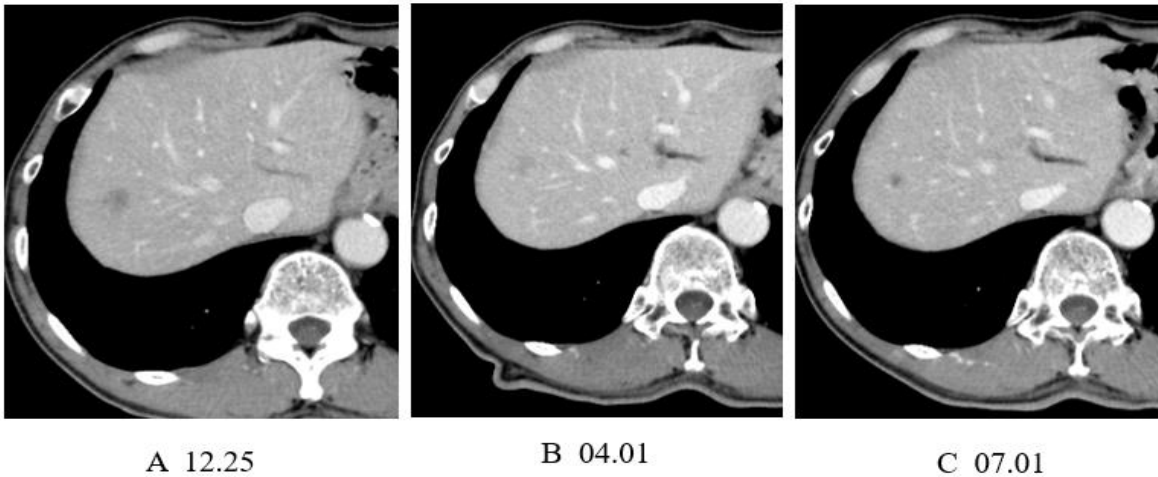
As time went by, a hypo-vascular space occupying lesion at S8 that is suspicious of metastatic tumor from gastric cancer is being shrunk on CT following receiving chemotherapy.
